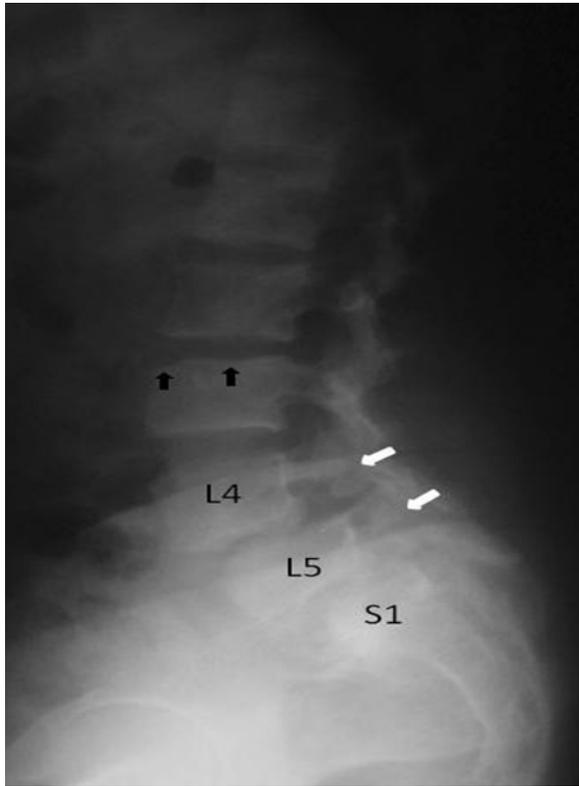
Lateral radiograph of the lumbar spine shows focal erosions at the superior end plate of L3 vertebra with disc space narrowing of L2-3 (black arrows). There is also spondylolisthesis at L4-5 and L5-S1 levels and associated pars defects, spondylolysis (white arrows). Prominent end plate degenerations, narrowing of central canal and neural foramina are seen at L4-5 and L5-S1.
